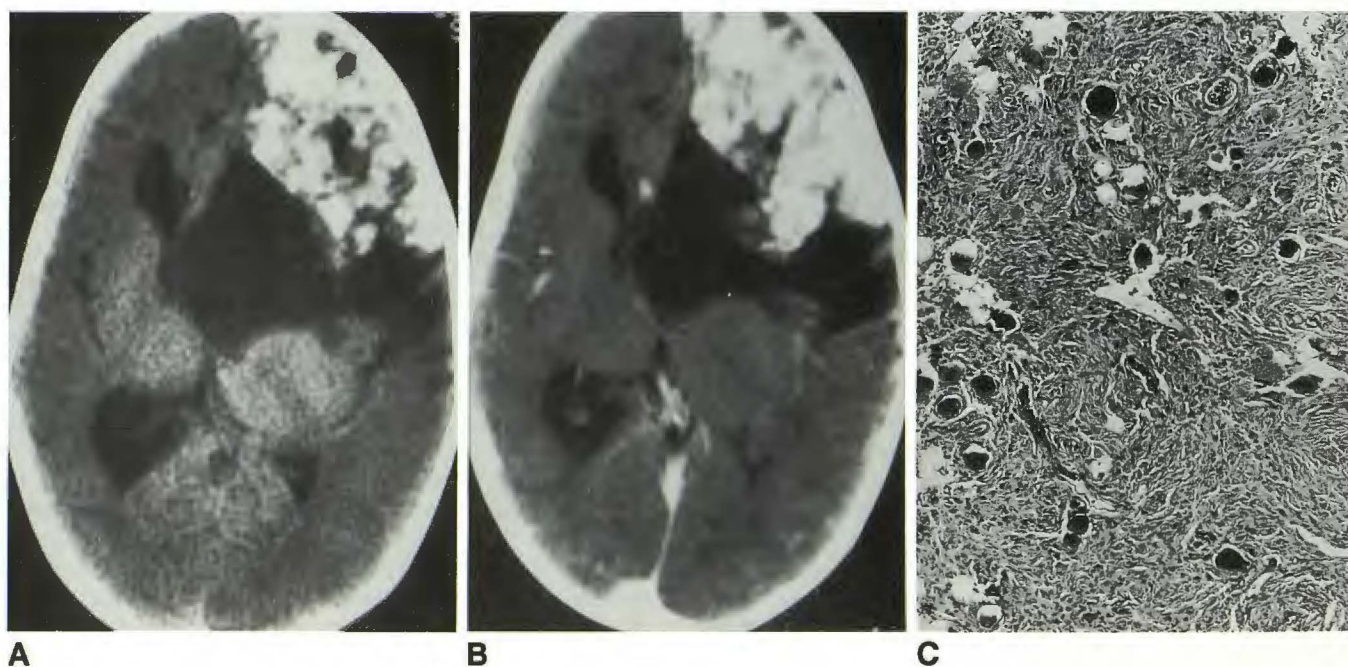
A, Unenhanced CT scan of the brain shows a large complex mass in left frontal region. Mass contains dense calcifications as well as cystic components. Compression of left lateral ventricle and shift of midline structures is evident.
